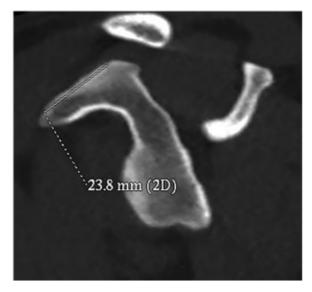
Measuring the length of the coracoid on the CT.
